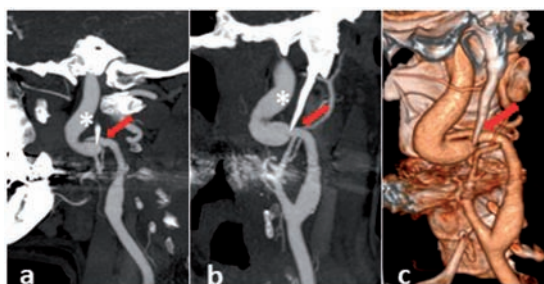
one-month CT-a (sagittal MIP-image in a, para-coronal MIP-image in b) demonstrating pseudoaneurismatic evolution of left cervical ICA (*) and persistence of an intimal flap at the elongated styloid process contact with internal carotid artery (red arrow). (c) VRT image showing in more details the elongated styloid process (red arrow) impression on the wall of the left ICA.
